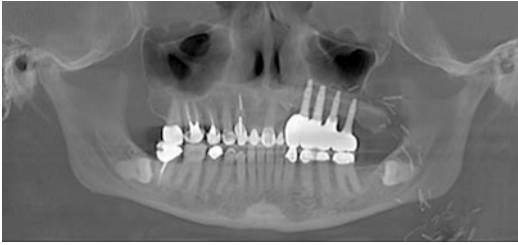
Panoramic radiograph showing implants placed within fibula flap reconstruction of Brown and Shaw Class II maxillectomy
